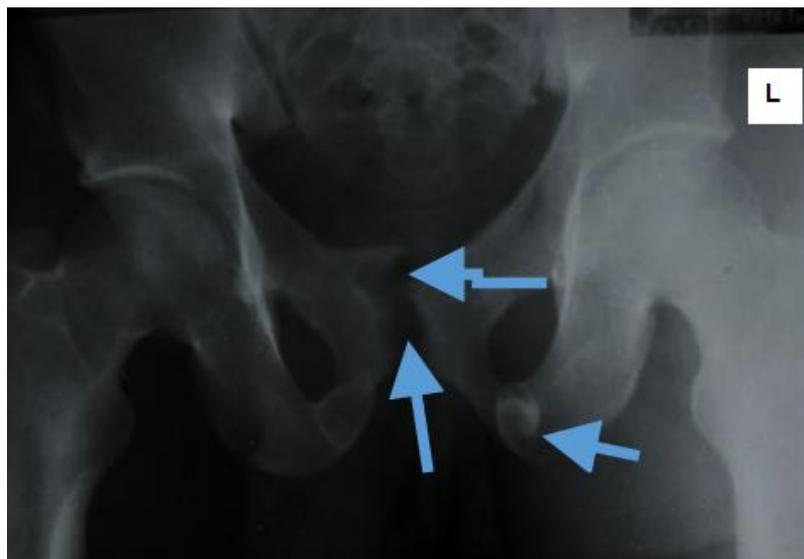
X-ray of the Pelvis AP view: Avulsion fractures of the left pubic tubercle and ischial tuberosity (horizontal arrow) (short arrows) respectively. Note sutural diastasis of the pubic symphysis (vertical arrows) and pelvic asymmetry, in keeping with vertical shear pelvic fracture
